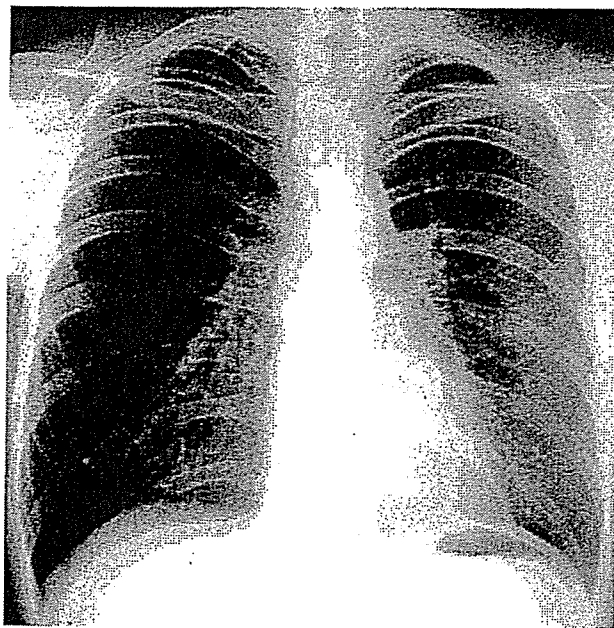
Four months after irradiation, chest X-ray showed an increased density in the left lung.
